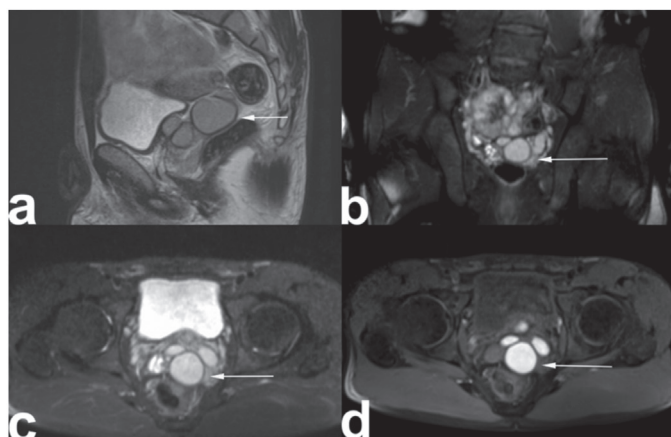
a) Sagittal T2 weighted image (WI), b) coronal and, c) axial fat-saturated T2WI magnetic resonance imaging images shows dilated, multiple cystic intercommunicating left seminal vesicle cyst, hypointense according to urine. d) Axial T1WI shows hyperintense multiloculated left seminal vesicle cyst, reflecting probably increased concentration of proteinaceous fluid or haemorrhage (arrows)
